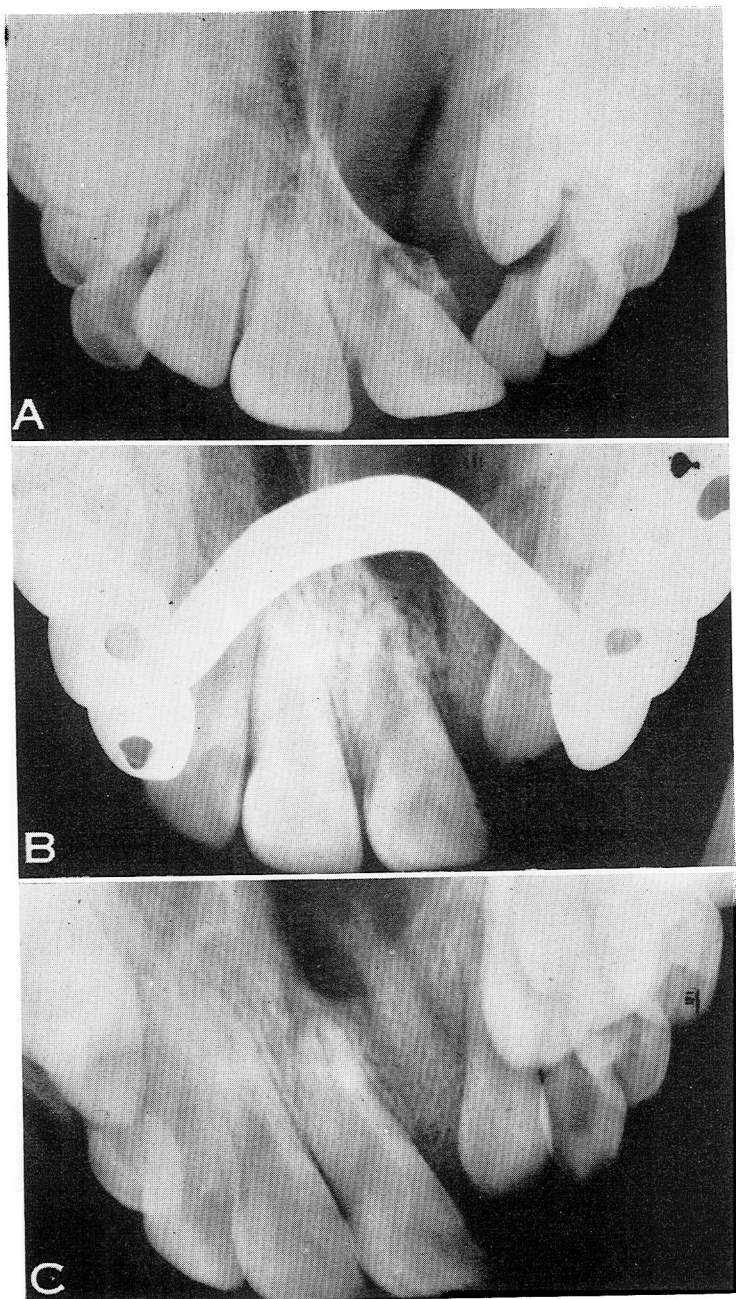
Occlusal radiographs of typical patient, (a) before treatment, (b) during retention, (c) post retention.
